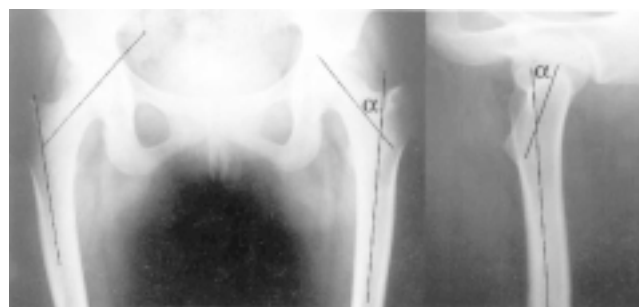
Showing the estimation of femoral neck anteversion by the biplanar X-rays method, (α) being the angle between the neck and shaft axis.
